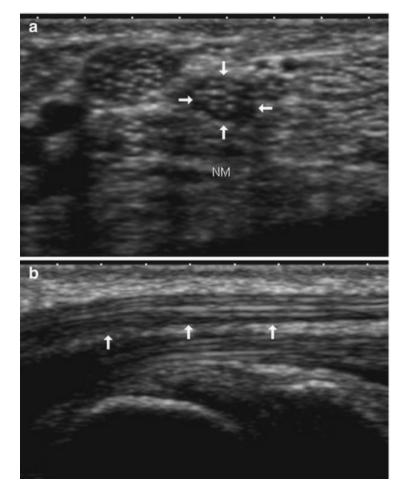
Normal appearance of the median nerve. (a) Short axis ultrasound image shows the peripheral median nerve (arrows) as an oval structure, consisting of a network of hypoechogenic fascicles separated by hyperechogenic septa. (b) Longitudinal ultrasound image shows the median nerve (arrows) as a tube containing hypoechogenic bands separated by hyperechogenic lines
